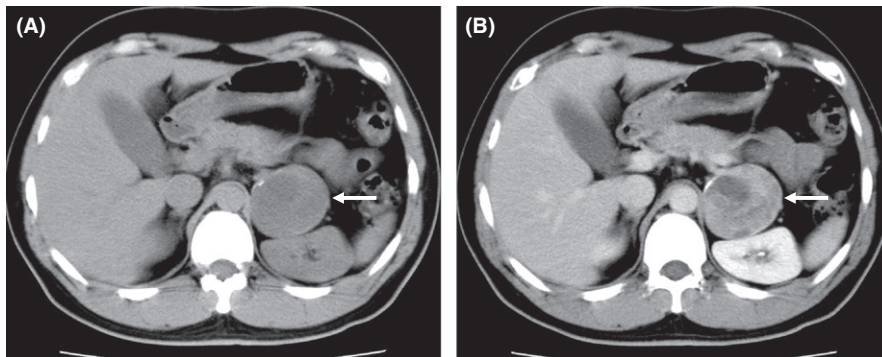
Computed tomography (December 2012). A, Plain computed tomography (CT) scan showing a 6-cm left adrenal tumor with calcification at the margin (arrow). B, Contrast-enhanced CT scan showing inhomogeneous enhancement in the tumor (arrow)
